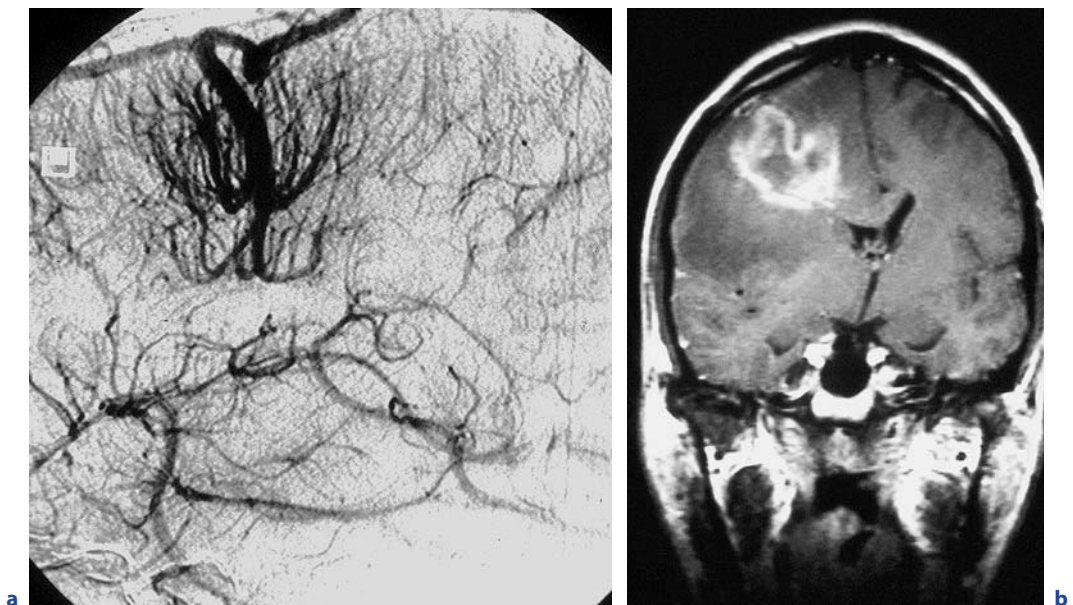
a Digital subtraction angiography of an unusual large developmental venous anomaly of the right hemisphere. Note the doubled upside-down umbrella with two Medusa heads and a single transcerebral draining vein. For unknown reasons, the patient received stereotactic radiation therapy and came back to the hospital 9 months later. b The magnetic resonance image at that time revealed a massive hemispheric swelling due to a large venous infarction after radiation-induced thrombosis of the collector vein
